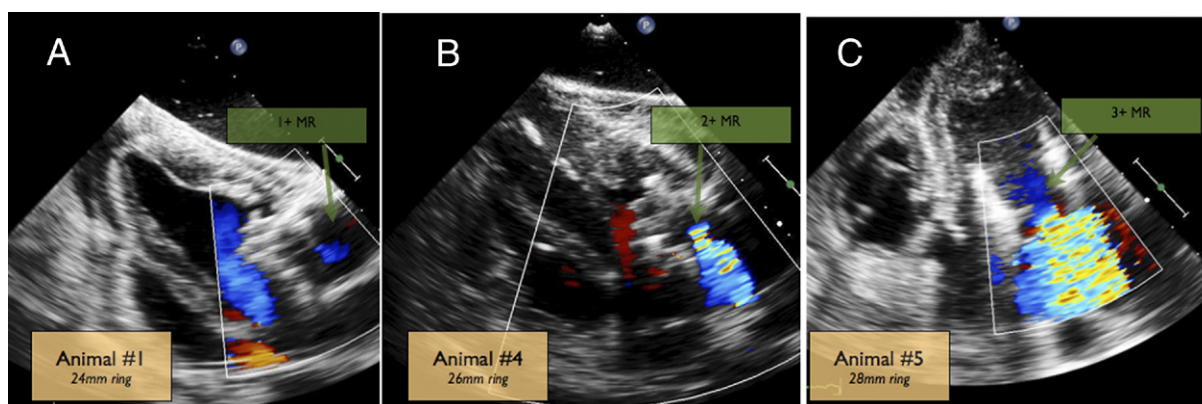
Doppler Echocardiography Following Melody VIR Procedure
